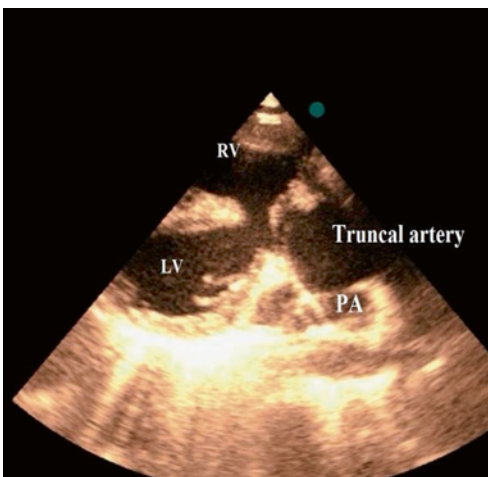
Transthoracic echocardiography in parasternal long-axis and apical off axis view showing a large VSD, overriding truncal artery, and the main pulmonary artery
